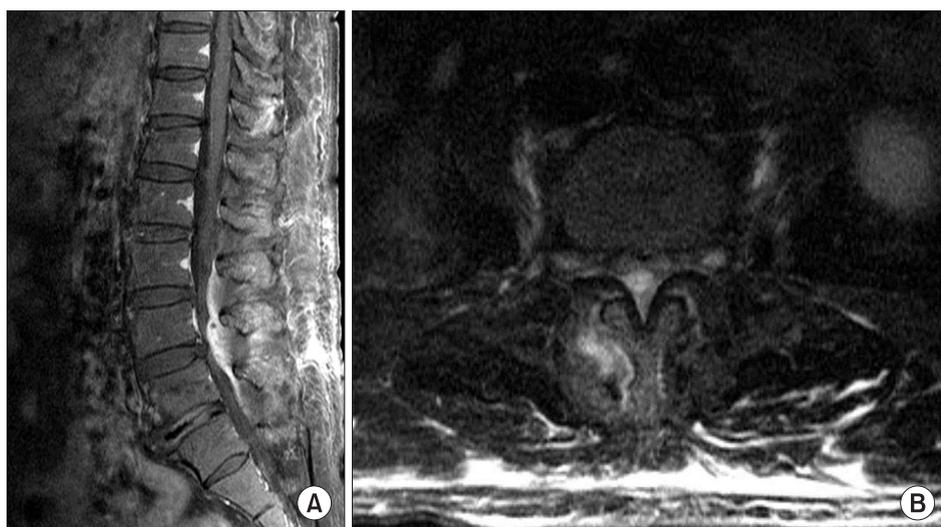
Preoperative imaging studies of epidural abscess. (A) Preoperative sagittal T1-weighted enhanced magnetic resonance image shows protruded disc material at lumbar 4–5 level and epidural lesion showing a high signal, compressing thecal sac at lumbar 4–5 posterior epidural lesion. (B) Axial T1-weighted enhance magnetic resonance image shows an abscess lesion showing high signal at the right facet joint and adjacent muscle.
